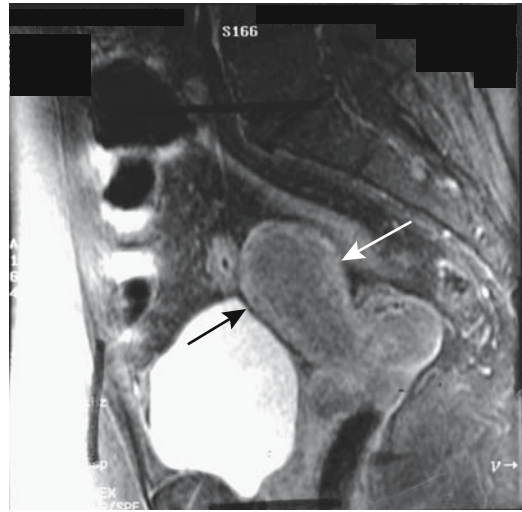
Cervical carcinoma. Contrast-enhanced sagittal MR image identifies a cervical tumor (arrows) having similar enhancement to uterus. (Source: Burgener FA, Meyers SP, Tan RK, Zaunbauer W. *Differential Diagnosis in Magnetic Resonance Imaging*. Stuttgart: Thieme, 2002, with permission.)
